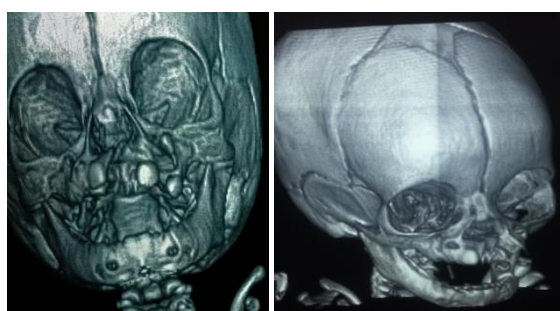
CT scan with contrast (3D view)
